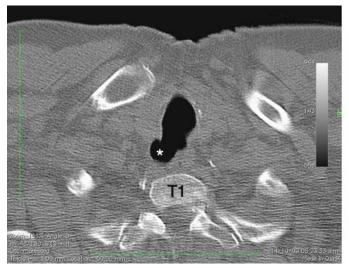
Left: Computed tomography scan at first thoracic vertebra level (T1) showing the tracheal diverticulum (*) as a pouch at the right posterolateral wall. Right: Broncoscopy image showing the collapsed diverticulum's openning.
